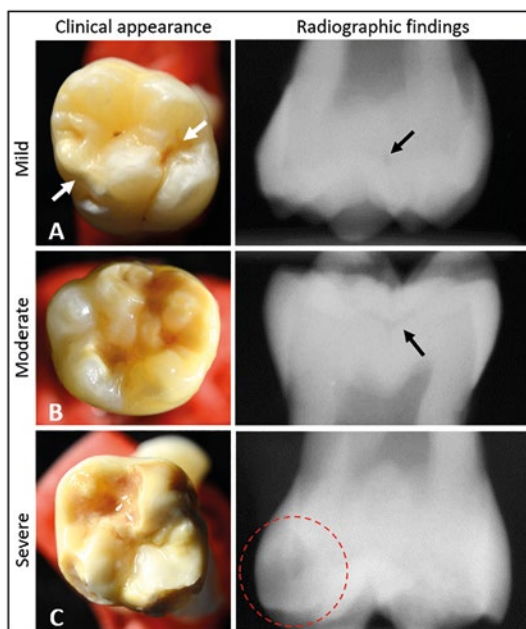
Clinical and radiographic criteria for interim treatment options and needs in cFPMs. a) Mild case: localised white creamy and/or yellow-brown discolourations (white arrows) without post-eruptive breakdown (PEB) or carious cavitation. No radiographic signs/changes restricted to the enamel-dentine junction (black arrow). b) Moderate case: yellow-brown discolourations with enamel-restricted PEB. Radiographic changes are restricted to outer dentine (black arrow). c) Severe case: discolourations merging into PEB or cavitation involving dentine. Atypical restorations may be present. Radiographic involvement into middle third of dentine or beyond (red circle). Generally, the radiographic involvement in hypomineralised teeth is less than would be expected for equivalent carious teeth
